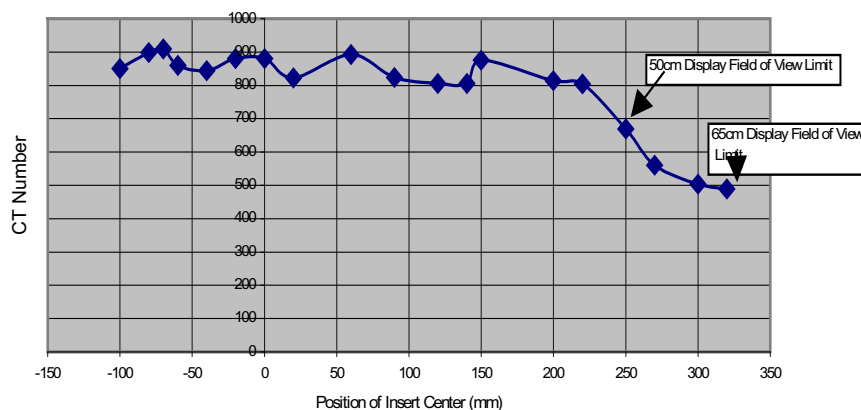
Variation in CT number of a bone insert with lateral position.
